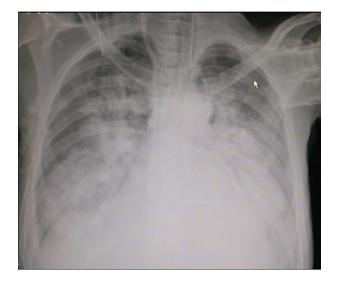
Chest X-ray of case 1 that shows bilateral diffuse airspace opacities with peribronchial cuffing.
